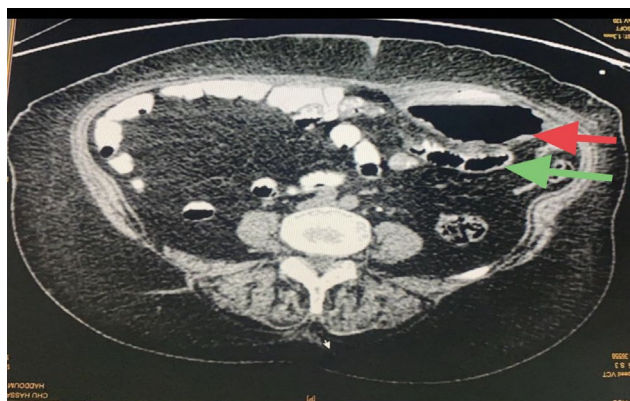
CT scan showed cavitated lesion with an air-fluid level in the left flank (red arrow), limited by thickened small bowel loops and apparently with luminal continuity (green arrow).
